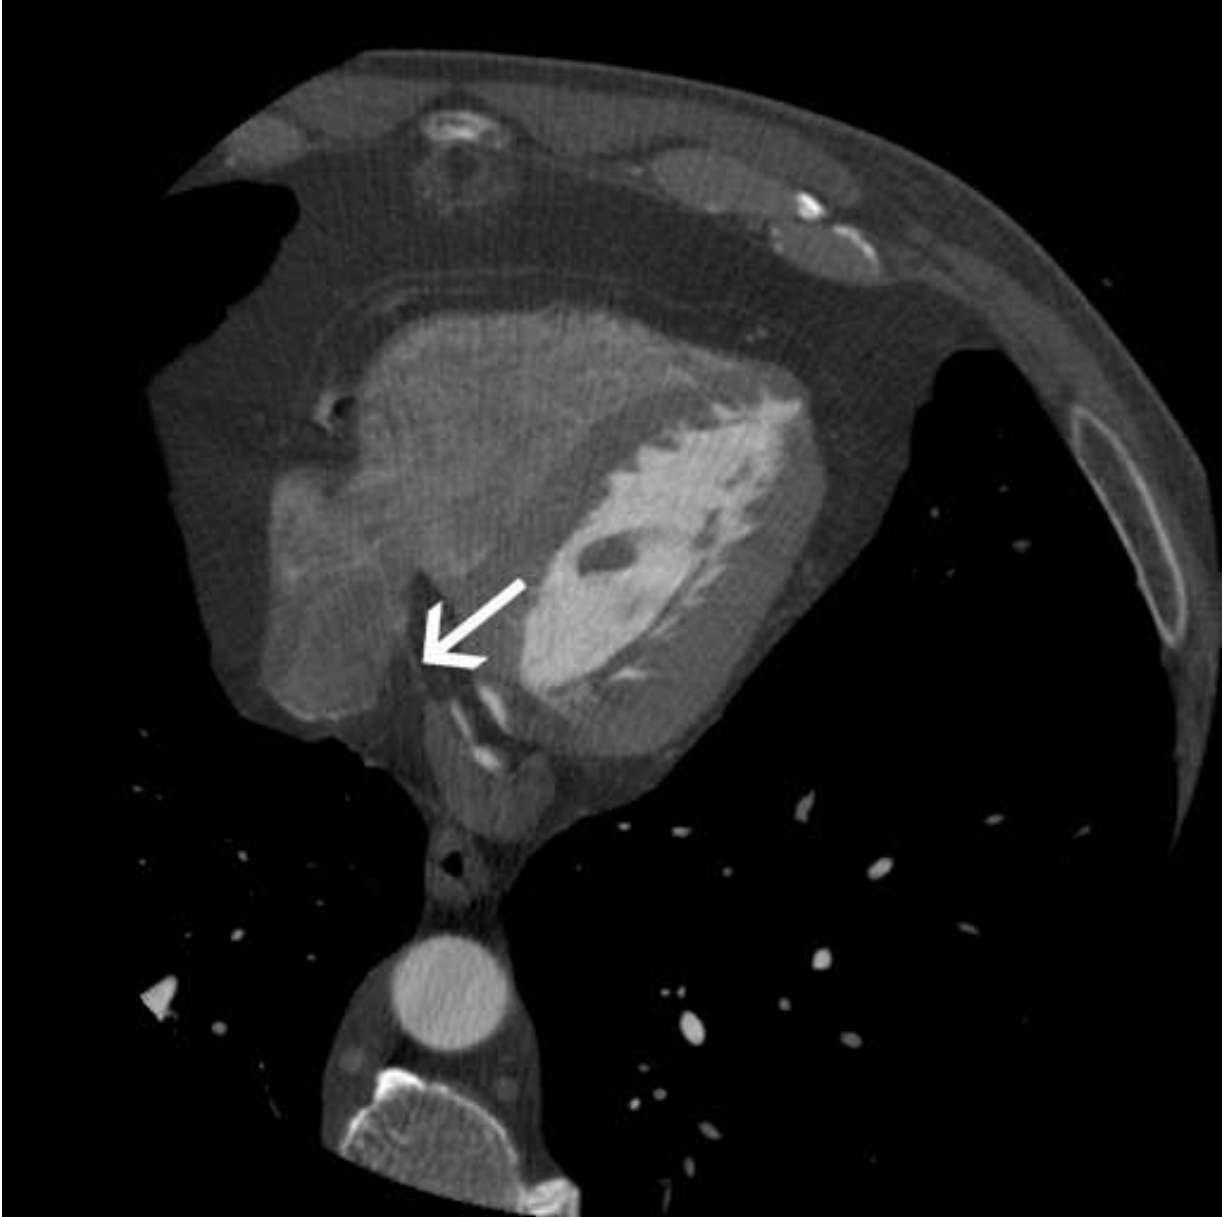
Axial scan, CT. Narrowing of coronary sinus (arrow) ostium.
